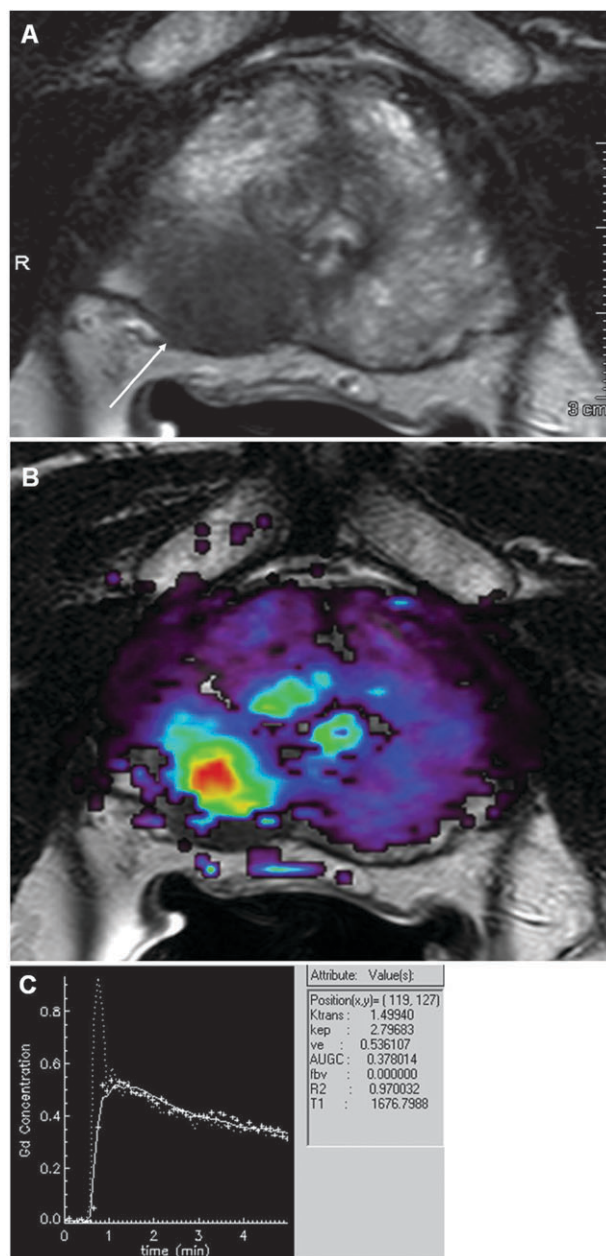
(A) Axial T2 image of prostate with a tumor (arrow). (B) DCE-MRI using low molecular weight contrast agent (Gd-DTPA). (C) Time intensity curve from site of tumor demonstrating rapid and strong rise, intense peak enhancement with subsequent wash-out, which is characteristic for highly angiogenic malignant tumors. Courtesy of Dr Baris Turkbey, Molecular Imaging Program, NCI/NIH.
